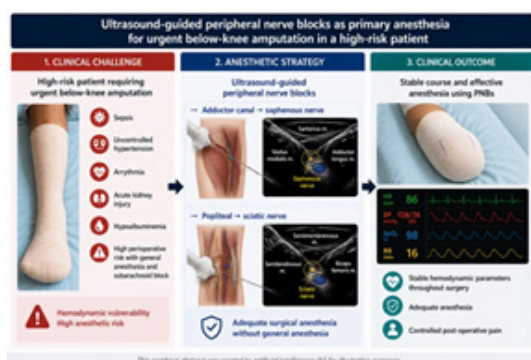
Ultrasound-guided adductor canal and popliteal sciatic nerve blocks provided adequate surgical anesthesia for urgent below-knee amputation in a high-risk septic patient, with stable intraoperative hemodynamic parameters and controlled postoperative pain.
